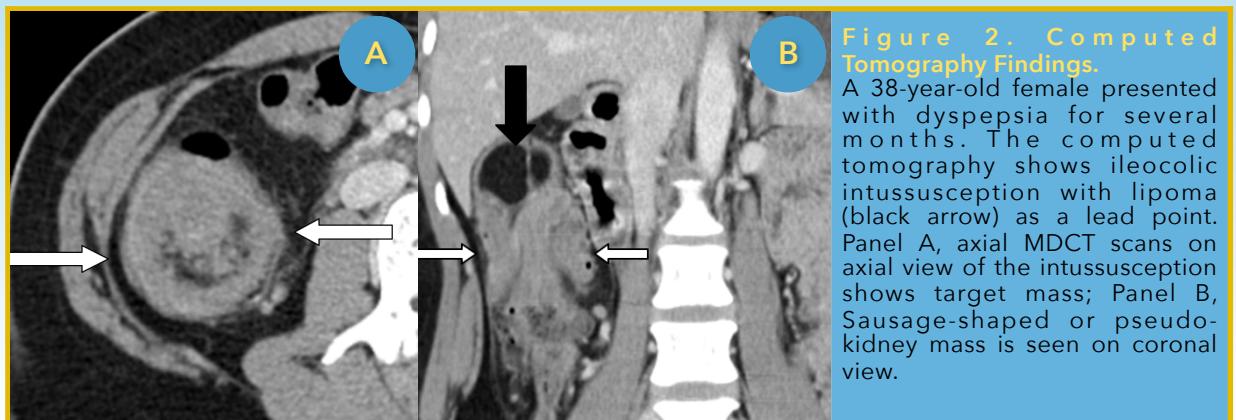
Computed Tomography Findings.
